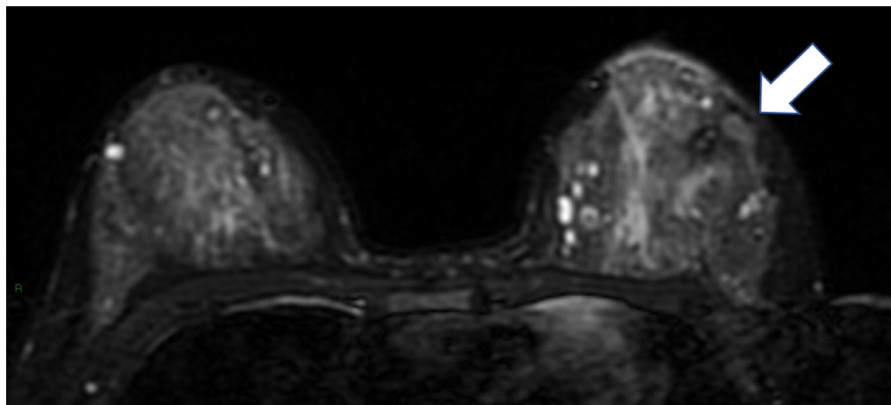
A hyperintense mass was seen on fat-suppressed T2-weighted imaging of the left breast (arrow).
